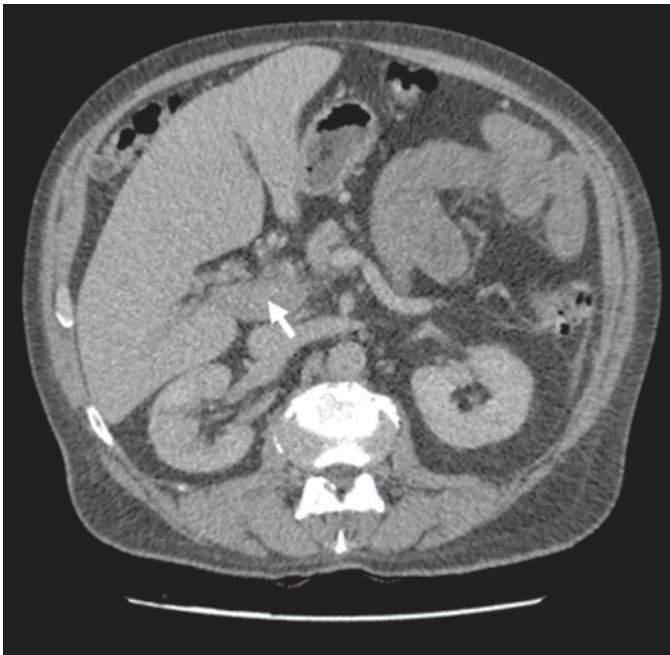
Follow up computed tomography abdomen-pelvis with contrast, showing extension of thrombosis up to the portal vein (white arrow).
